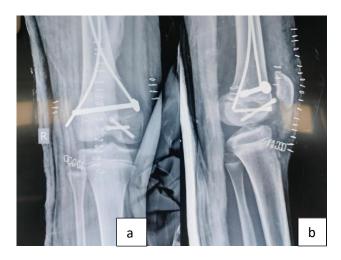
(a and b): Post-operative antero-posterior and lateral X-ray views of right knee showing Hoffa fracture of medial femoral condyle fixed with HCS and CCS.
